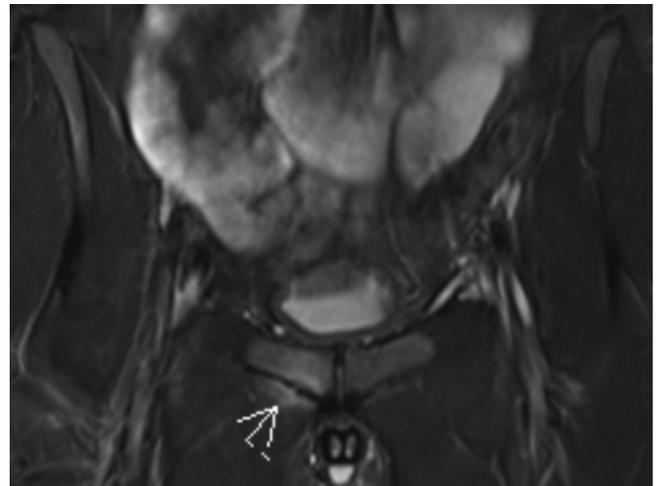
Coronal short tau inversion recovery magnetic resonance imaging sequence demonstrating edema at the adductor longus insertion in a patient with adductor tendinopathy (white arrow).
